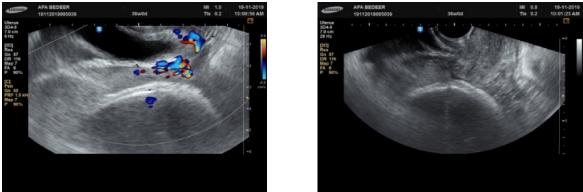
Ultrasound imaging of case 10
